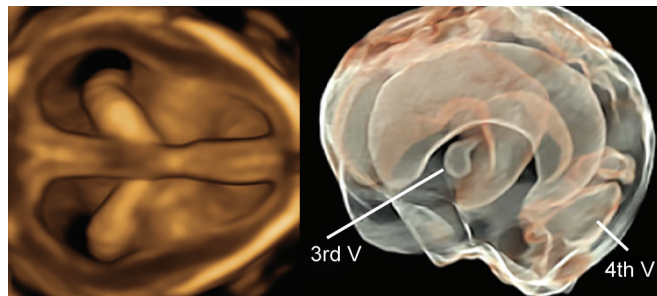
Ventriculomegaly associated with Dandy Walker syndrome at 16 weeks of gestation: Left: Conventional three-dimensional axial image of the brain. Bilateral ventriculomegaly is visible, and Right: HDlive silhouette image. Enlargement of bilateral lateral ventricles, third ventricle (3rd V), and fourth ventricle (4th V) is well demonstrated inside the brain and orientation of ventricular system is well understandable by silhouette ultrasound
